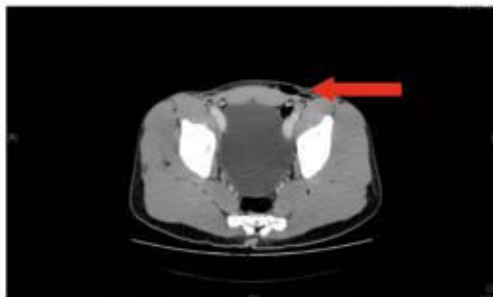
Abdominopelvic CT scan: subcutaneous emphysema extending from the anterior left scrotum to the pubic symphysis.
